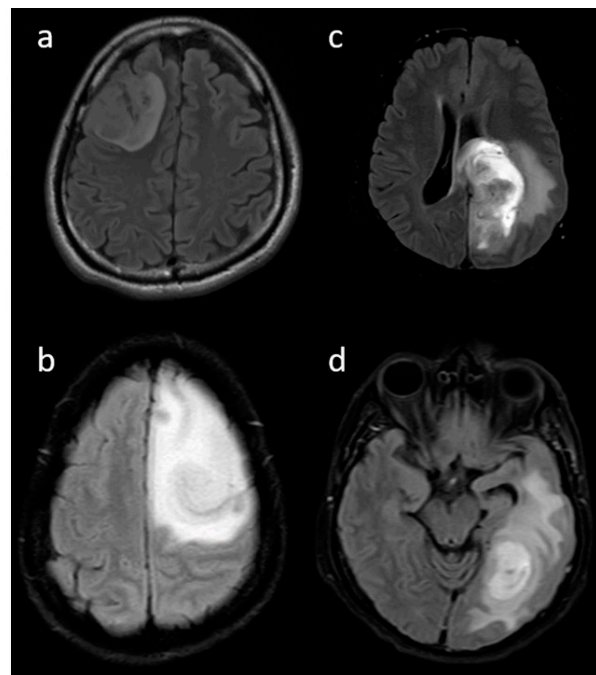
(a–d) Representative FLAIR images showing various proportions of edema: (a) none, (b) less than tumor volume, (c) equal to tumor volume, and (d) more than tumor volume.
